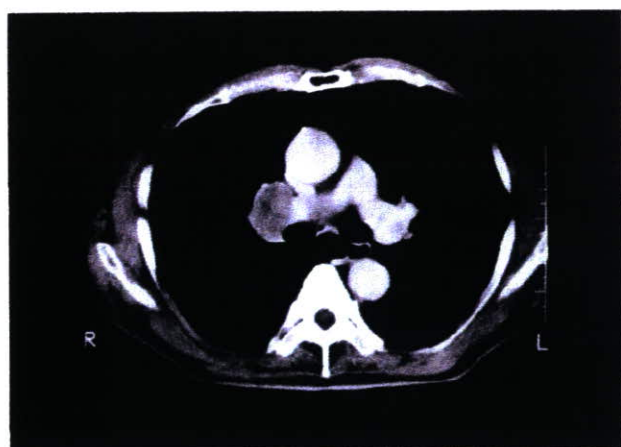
Computed tomography scan showing enlargement of the right hilar lymph nodes
